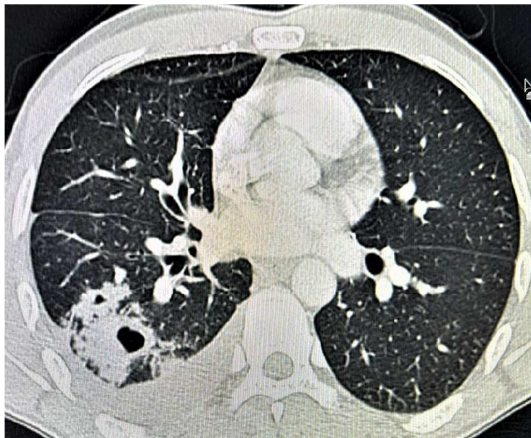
Image of pulmonary tuberculosis on CT scan.
